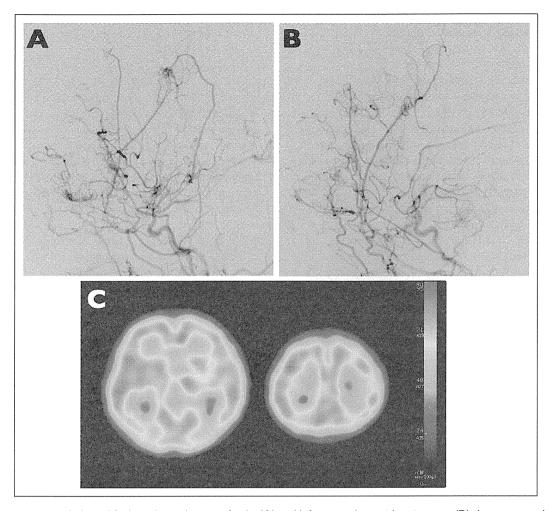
Postoperative radiological findings. Lateral views of right (A) and left external carotid angiograms (B) demonstrate that surgical collaterals widely provide the blood flow to the operated hemispheres. C, N-isopropyl-p-[1231]iodoamphetamine single-photon emission computed tomography (SPECT) reveal that cerebral blood flow almost normalized after surgery.
